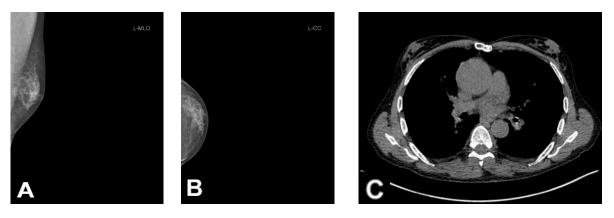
Gynecomastia on MM image (A, B) and CT image in a male known with cirrhosis (C).
